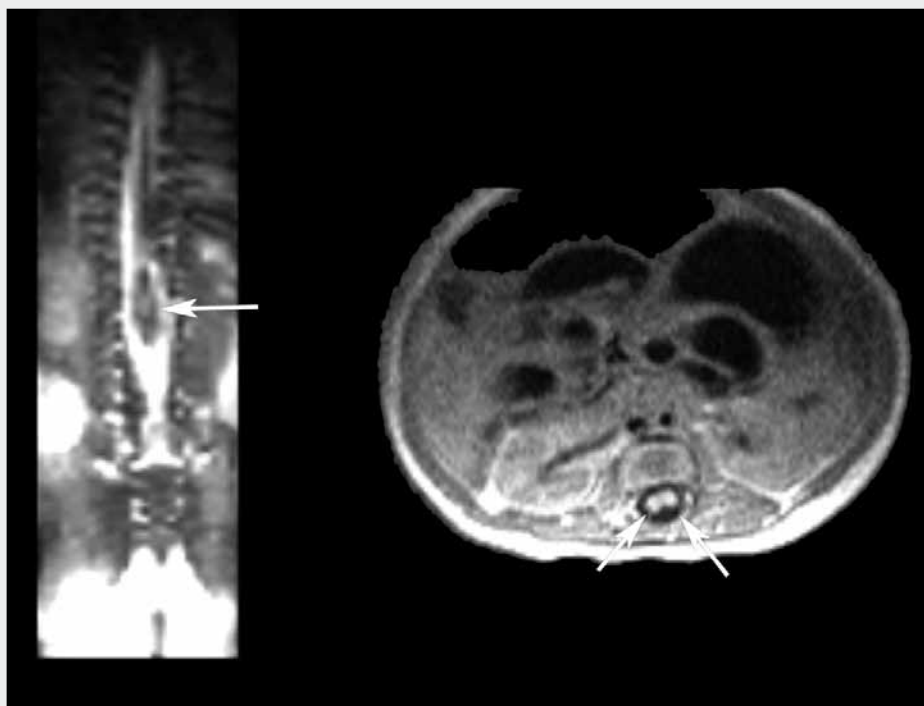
Postnatal MRI with diastematomyelia finding
